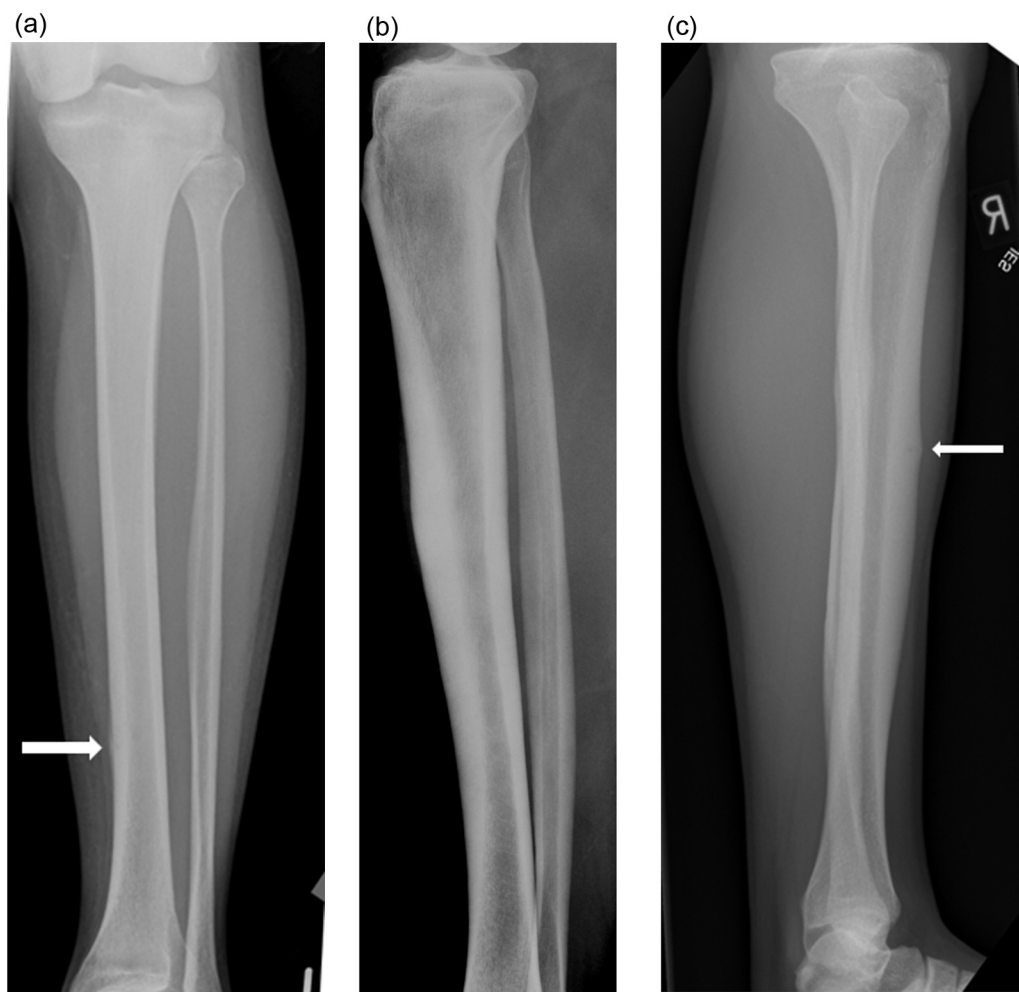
(a) AP radiograph of the leg demonstrating a periosteal reaction associated with a stress fracture (arrow). (b) Lateral radiograph of the leg, showing diffuse cortical thickening of the anterior tibial diaphysis. (c) Lateral radiograph of the leg demonstrating a subtle linear lucency (arrow).
